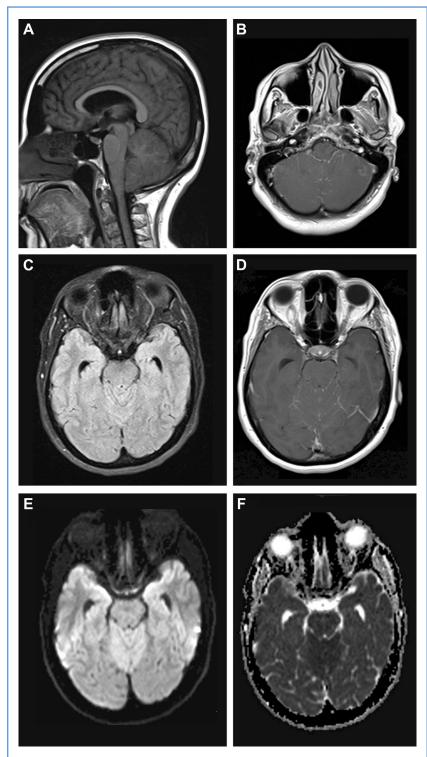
Brain magnetic resonance imaging. (A) Sagittal T1-weighted sequence showing diffuse cerebellar swelling with herniation of the cerebellar tonsils through the foramen magnum. (B) Axial T1-weighted contrast-enhanced sequence revealing diffuse leptomeningeal smooth enhancement. (C) Axial fluid attenuated inversion recovery sequence showing a high-intensity signal in the bilateral cerebellar folia owing to cerebellar edema. (D) Axial contrast-enhanced T1-weighted sequence revealing leptomeningeal enhancement in the cerebellar vermis. (E and F) Axial diffusion-weighted and apparent diffusion coefficient sequence showing diffusion restriction in the cerebellar vermis.
